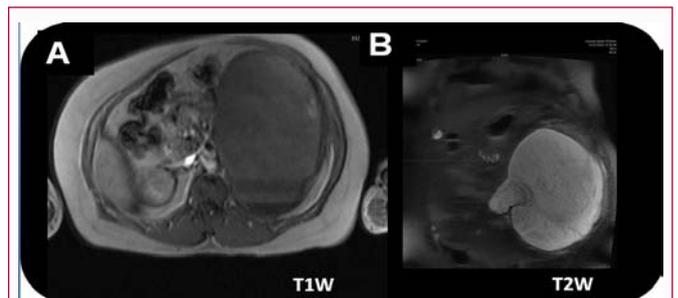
MRI was advised for further characterization, but unfortunately the examination was terminated early due to the patient's claustrophobia. Only two limited T1- and T2-weighted sequences were performed. T2 weighted images demonstrated somewhat heterogeneous hyperintense signal. T1 weighted images demonstrated low signal intensity.
